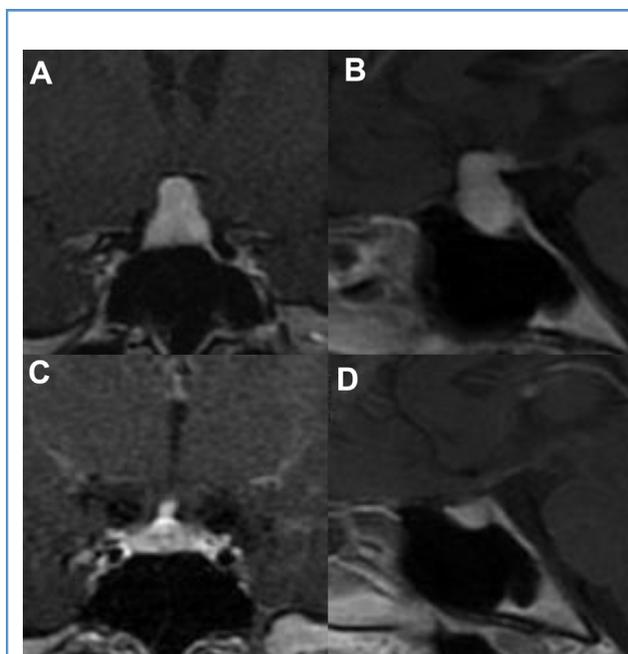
(A–D) Example of case 12 in Table 1. This female patient presented with a headache, vision changes, and diabetes insipidus in the 2 months post partum. Magnetic resonance imaging showing the marked changes after initial steroid pulse therapy. At baseline, the coronal (A) and sagittal (B) T1-weighted magnetic resonance imaging showed homogeneously enhanced pituitary mass, thickened pituitary stalk, and compressed optic chiasm. The contrast-enhanced coronal (C) and sagittal (D) showed significant shrinkage in sellar mass and suprasellar extension after receiving steroid pulse therapy for 4 months. The patient's symptoms resolved almost completely except for mild diabetes insipidus, and she showed partial recovery of anterior pituitary dysfunction.
